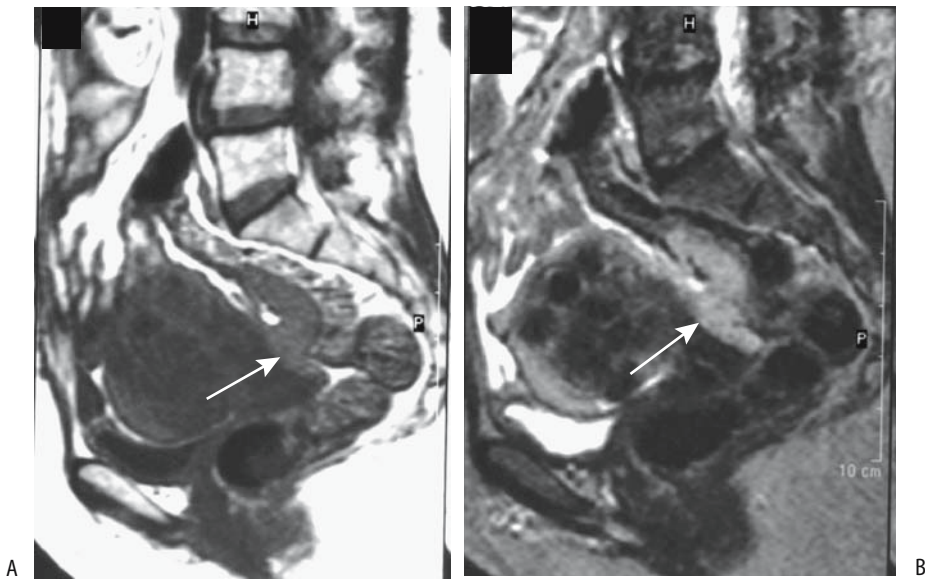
Recurrent peritoneal mesothelioma. A: A T1-weighted image identifies numerous uterine myomas. A tumor isointense to muscle is present along the anterior wall in the pouch of Douglas (arrow). B: This tumor is slightly hyperintense on a T2-weighted image (arrow). (Courtesy of Egle Jonaitiene, M.D., Kaunas Medical University, Kaunas, Lithuania.)
